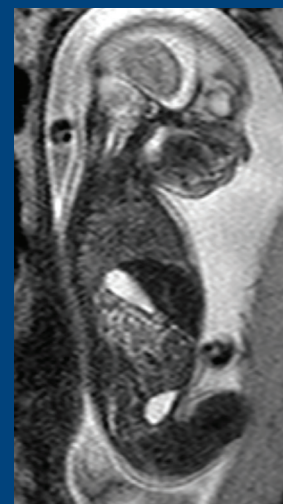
BTFE MRI image.
